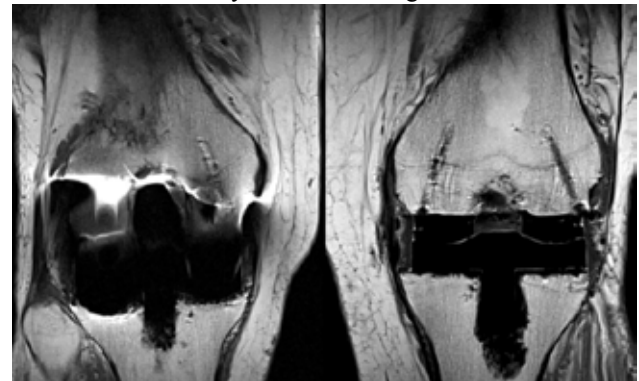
MRI images of the CoCr (left) and PEEK femoral components, with noticeable distortions around the CoCr implant.
